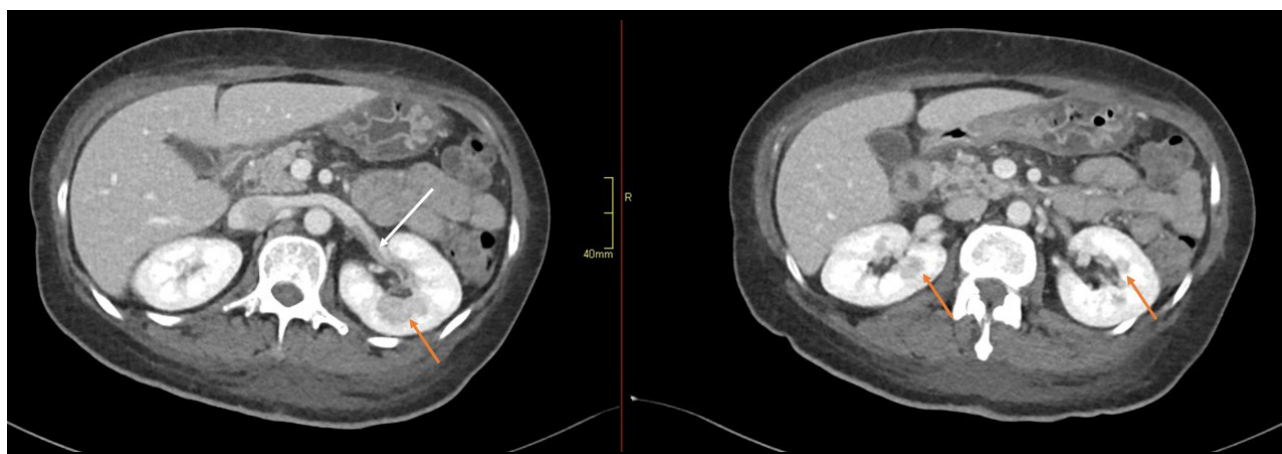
Contrast-enhanced computed tomography scan showing bilateral patchy renal parenchymal hypodensities suggestive of pyelonephritis (orange arrows) and left renal vein thrombosis (white arrow).
